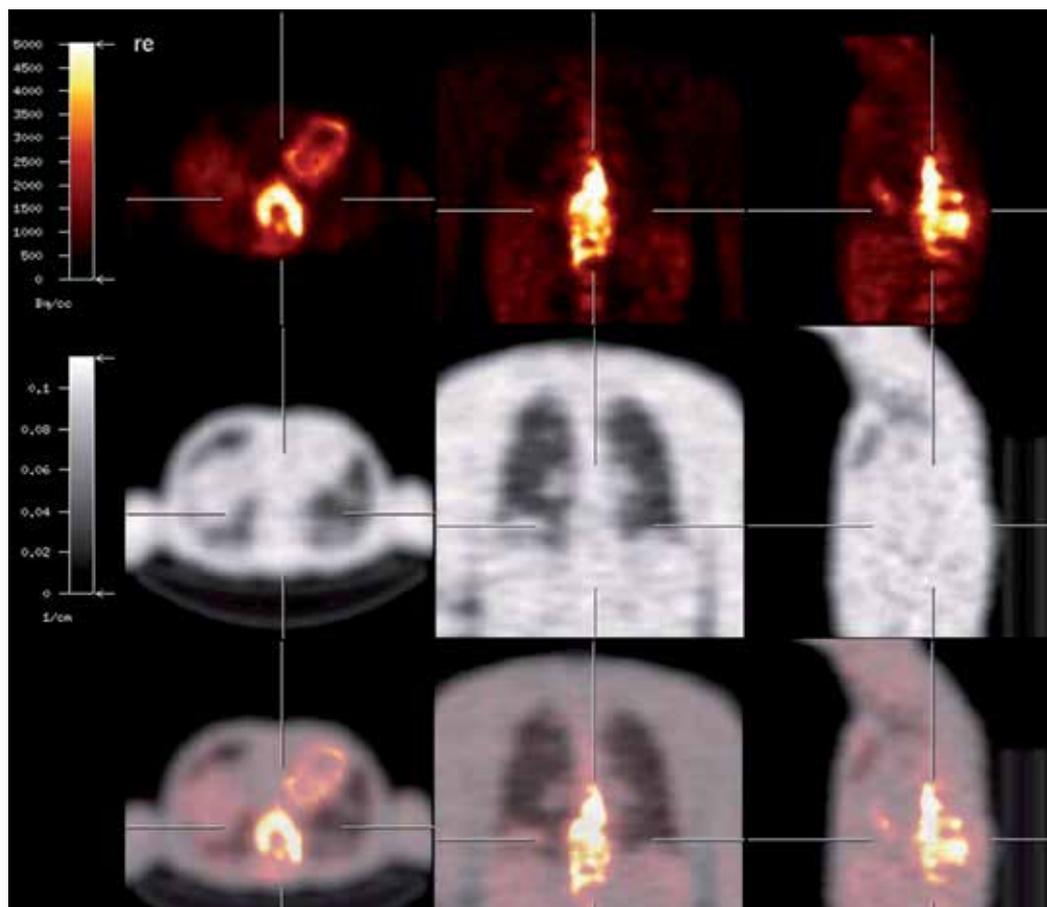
Spondylodiscitis (*Mycobacterium Xenopi*). Positron Emission Tomography (PET) with 18-F-fluorodeoxyglucose as tracer (F18-FDG-PET) showing a pronounced increase in accumulation extending over several segments (approximately T9-T12) with a SUV (mean standard uptake value) maximum of 9.1.
